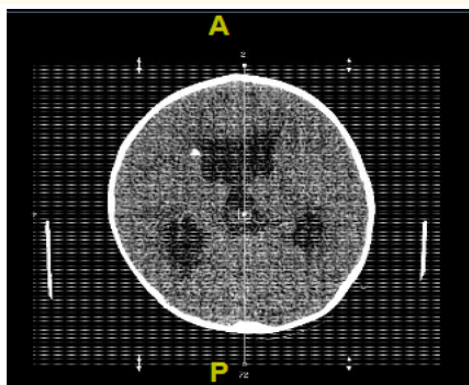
Head CT demonstrating hydrocephalus.
